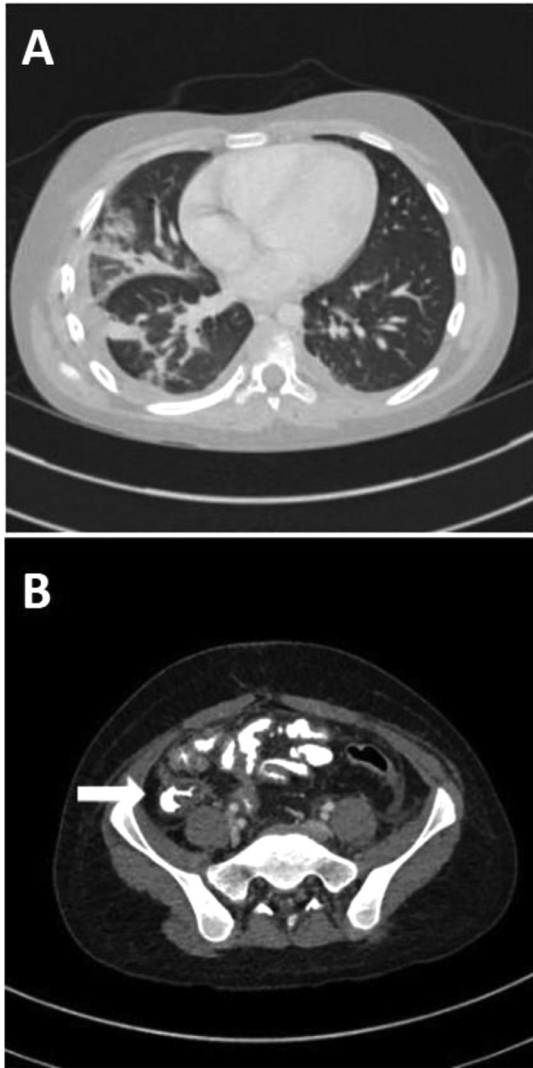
(A-B): (A) Axial image of a contrast-enhanced CT on postoperative day 8 demonstrating development of a right pleural effusion and increased areas of ground glass attenuation and parenchyma bands in the right middle lower lobes. New left effusion and minimal ground glass opacity are partially demonstrated. (B) Axial image of a contrast-enhanced CT with intravenous and oral contrast performed on postoperative day 8 showed no evidence of abscess formation, but residual colonic and terminal ileal mural thickening was present (arrow).
